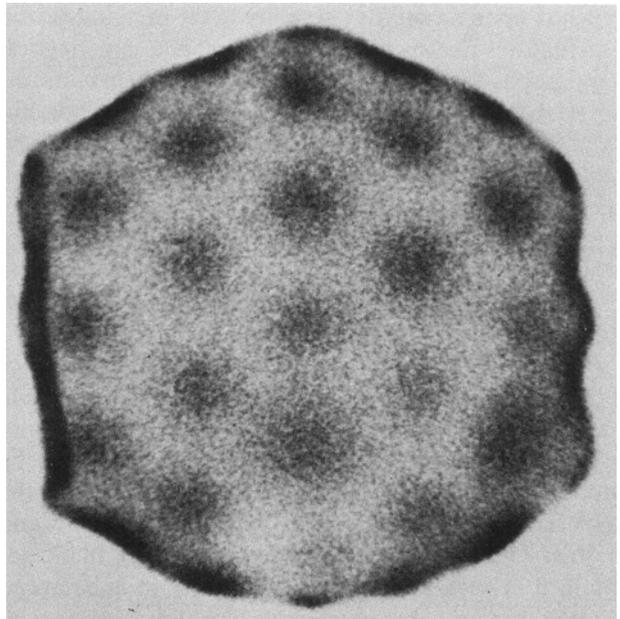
Scintigraph of unbalanced photomultiplier tubes using our technique. Note lighter PM-tubes in lower right quadrant. One darker tube, located at the top of the scintigraph, shows increased voltage supply.
